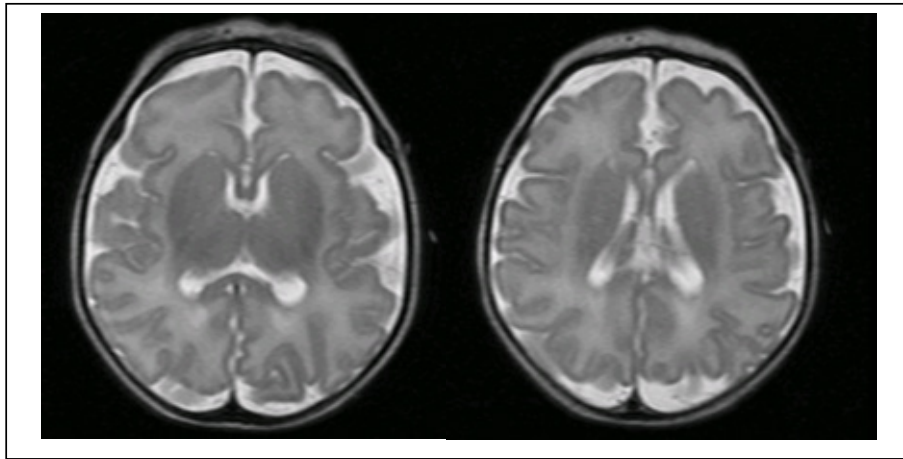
Brain MRI of age 6 weeks old demonstrated delayed myelination for age
